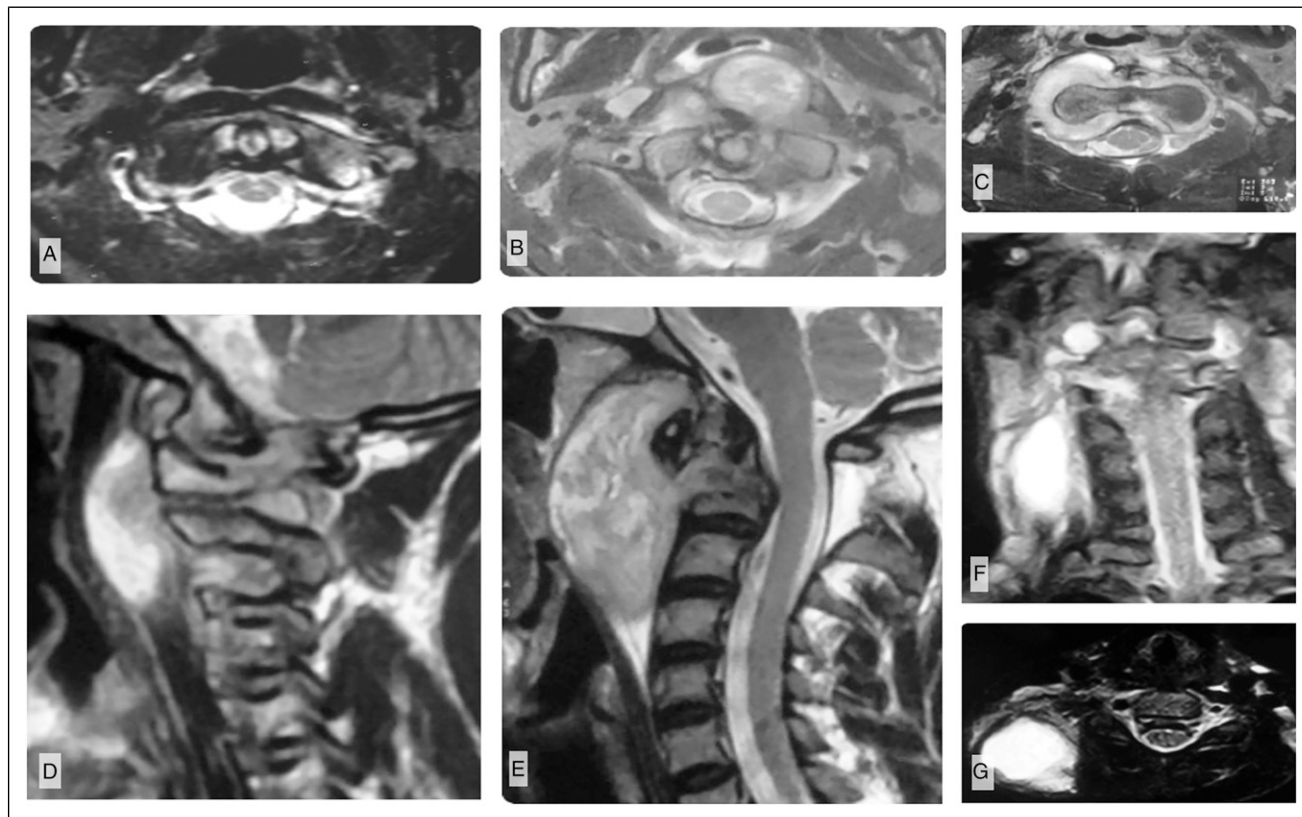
Abscess localization. (A) Axial T2-weighted MRI of patient with early-stage disease shows abscess formation within the prevertebral space, causing ventrally displacement of the prevertebral musculature (longus colli, longus capitis). (B) As the abscess expands, it predominately localizes around the synovial joints of the CVJ including the peridental region, (C) but it may also track laterally and through the neural foramina into the epidural space. (D, E) Sagittal T2-weighted MRI images demonstrate expansion of the prevertebral abscess, elevating the prevertebral muscles without violating the prevertebral fascia at any stage. (F) Coronal MRI showing a large, cold abscess that has tracked along the neurovascular bundles into the posterior triangle of the neck, which presents as a swelling on examination. (G) Axial MRI showing the same abscess in the posterior triangle of the neck.
